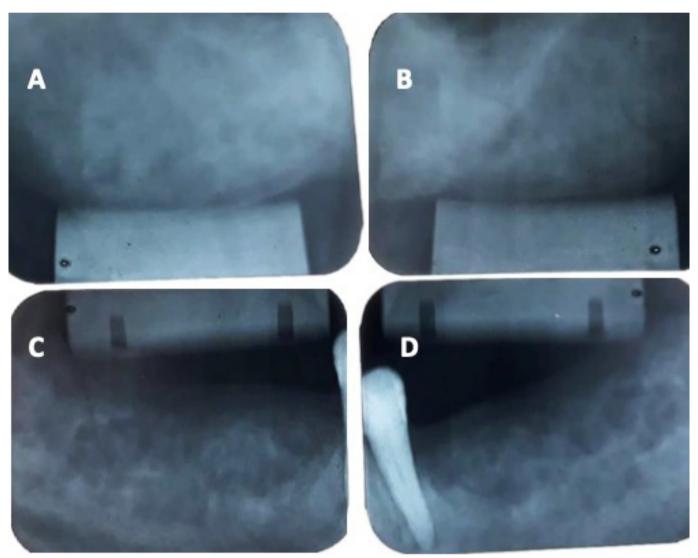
Periapical radiographs showing the posterior region of the right maxilla (A), posterior region of the left maxilla (B), posterior region of the right mandible (C), and posterior region of the left mandible (D). All images show a loss of cortical bone integrity and the multifocal presence of radiolucent spots, resembling the "salt and pepper" pattern described in the literature.
